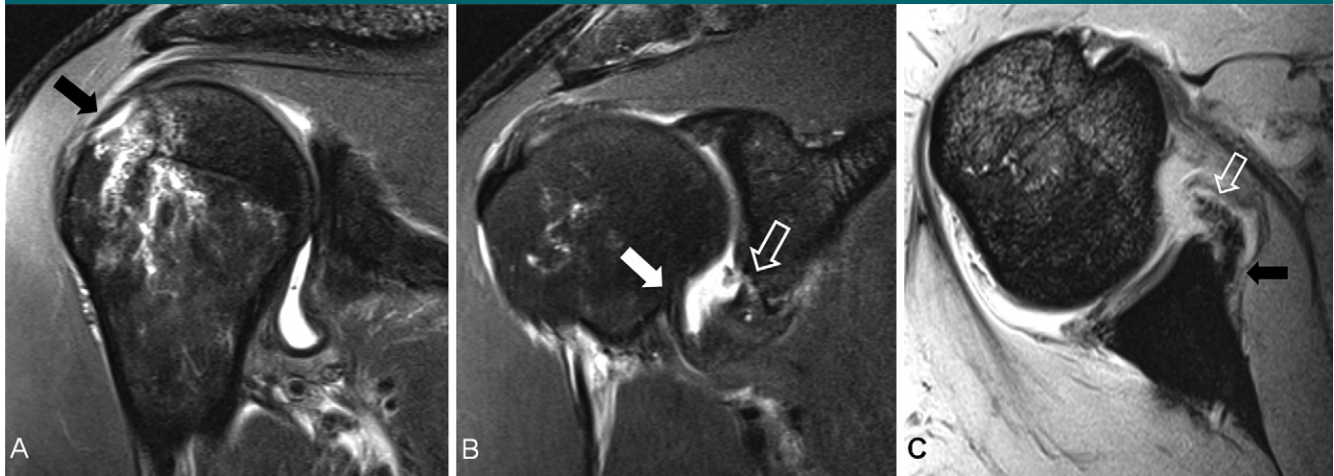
MR images in a 31-year-old male dancer obtained 4 days after acute first-time anterior shoulder dislocation. *A*, Oblique coronal fat-suppressed T2-weighted image shows a small Hill-Sachs fracture (arrow) with prominent bone marrow edema. Effusion is present. *B*, On more anterior oblique coronal fat-suppressed T2-weighted image, the inferior labral-ligamentous complex (open arrow) is detached and displaced from the inferior glenoid rim. The humeral attachment site (solid arrow) is unremarkable. The cuff is intact. *C*, On axial gradient-echo image, the anteroinferior labral-ligamentous complex (open arrow) is displaced from the glenoid rim, and the attached periosteum (solid arrow) is stripped medially along the glenoid neck. No glenoid rim fracture is present.
